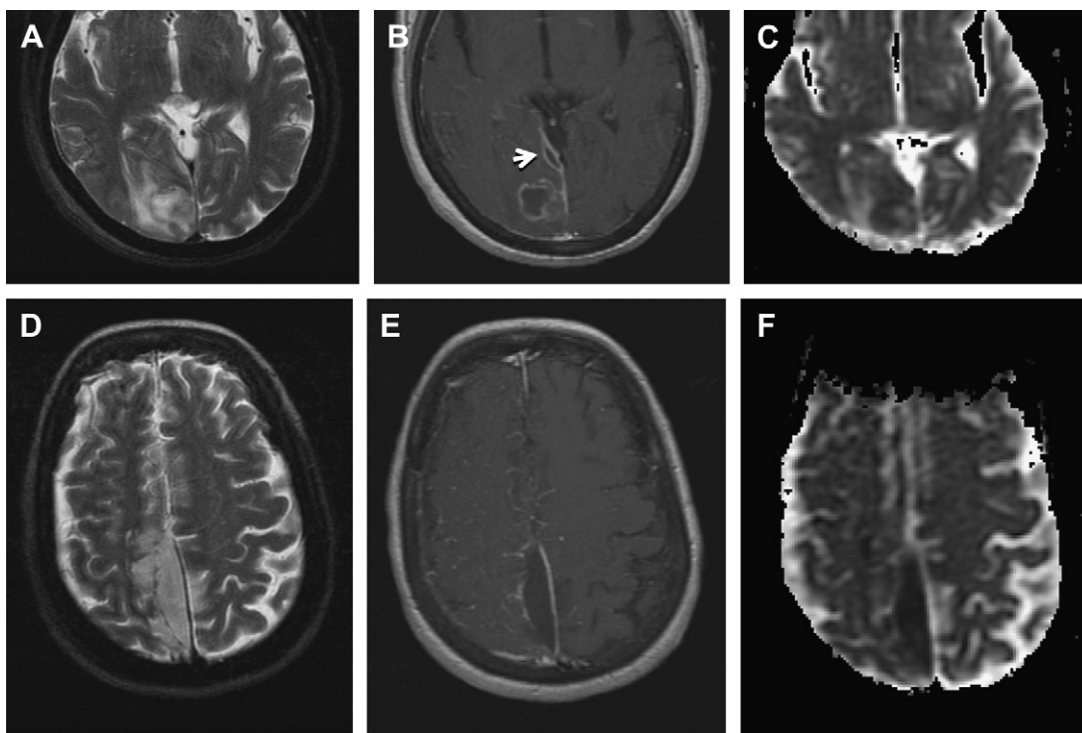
(A–C) Axial T2-weighted sequence, T1 postcontrast sequence, and ADC maps demonstrate a typical brain abscess in the right occipital lobe with central T2 hyperintense signal, surrounding rim enhancement, and hypointense signal on ADC, consistent with restricted diffusion. There is daughter abscess formation beginning along its medial margin. There is a rim-enhancing small subdural empyema along the right tentorium (*white arrow*). (D–F) There is an associated right posterior parafalcine T2 hyperintense rim-enhancing subdural fluid collection with reduced ADC, consistent with a subdural empyema. In addition, there is evidence of meningitis with leptomenigeal enhancement noted in the right cerebral hemisphere. (Courtesy of Barton F. Branstetter IV, MD, University of Pittsburgh.)
